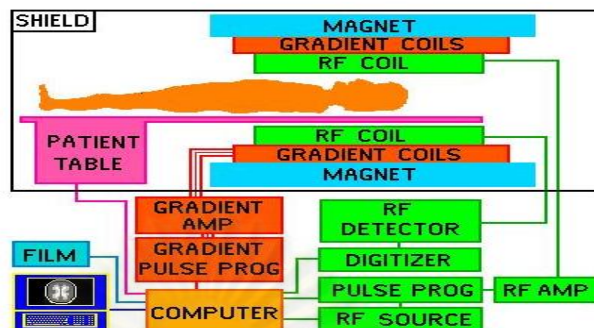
Basic components of MRI system
